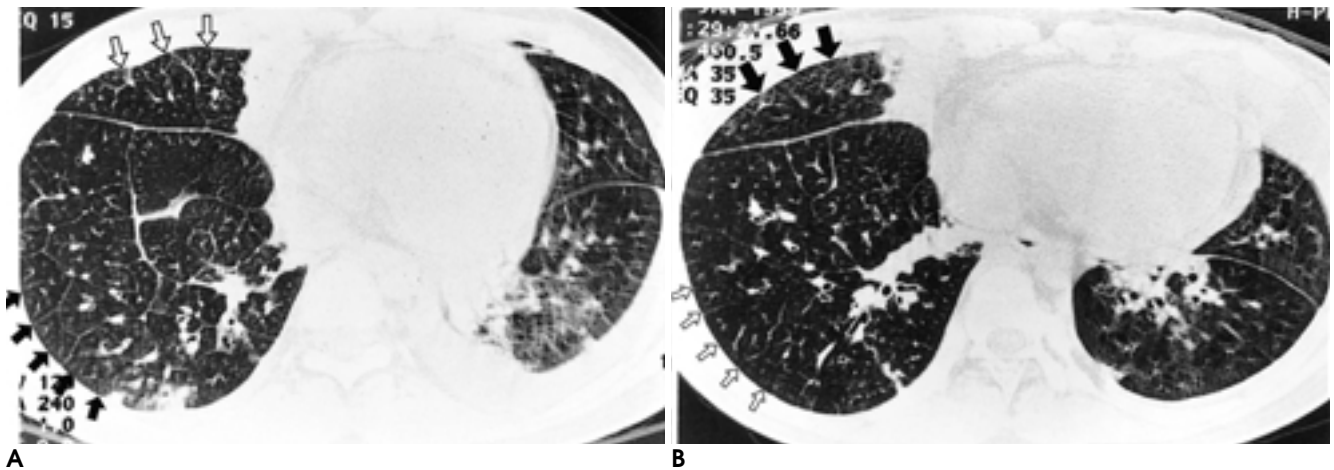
A 14-year-old girl with pulmonary edema due to pulmonary veno-occlusive disease. CT scans at the same level in supine (A) and prone (B) position show marked shifting of septal lines to gravity-dependent area (arrows). Note relative paucity of interlobular septal lines in non-dependent lung zone (open arrows). She was graded as high in degree of positional shifting of interlobular septal thickening.
